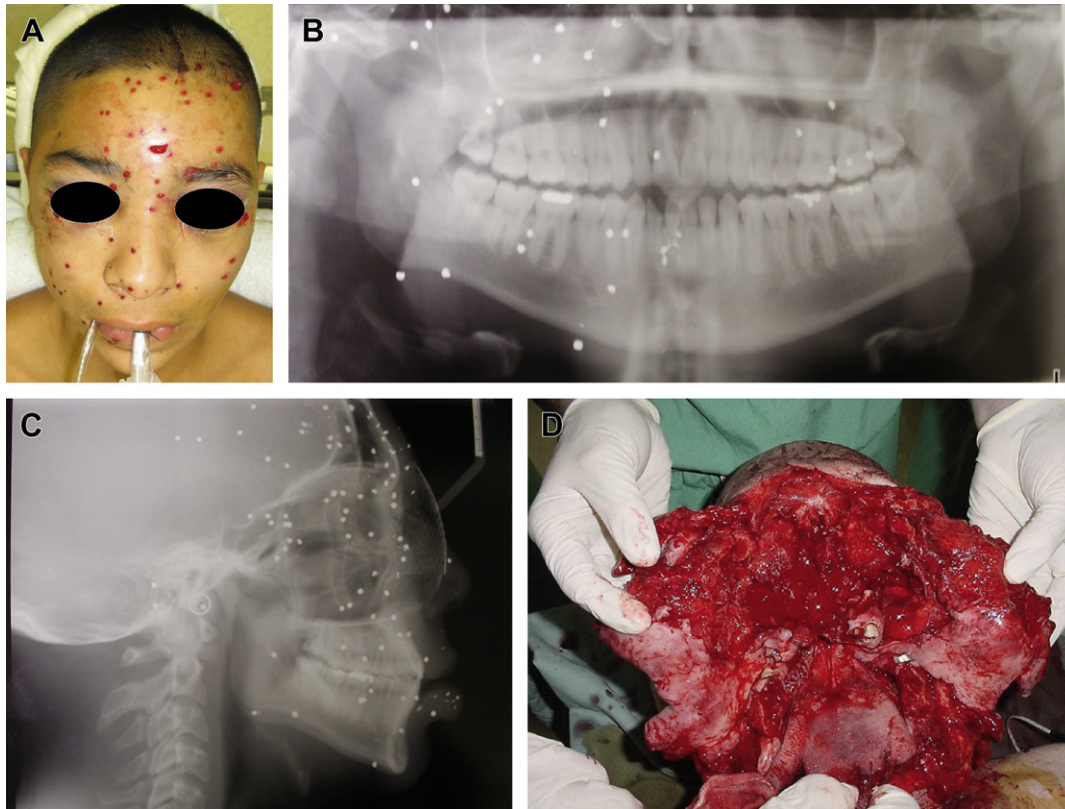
(A) Characteristic facial appearance of a patient sustaining a shotgun wound from a distance (Sherman and Parrish – Class I or Glezer – Class I). Note the presence of multiple punctate entry wounds, but no significant disruption of the facial features. (B, C) Classic radiographic appearance of a patient sustaining a shotgun wound from a distance (Sherman and Parrish – Class I or Glezer – Class I). Note the presence of multiple shotgun pellets on the radiographs. (D) Self-inflicted shotgun wound in a suicide attempt. Note significant hard and soft tissue disruption and avulsion (Sherman and Parrish – Class III or Glezer – Class III). ([A, D] From Powers DB, Delo RI. Maxillofacial ballistic and missile injuries. In: Fonseca RJ, Walker RV, Betts NJ, et al, editors. Oral and maxillofacial trauma. 4th edition. St Louis (MO): Elsevier Saunders; 2012; with permission.)
